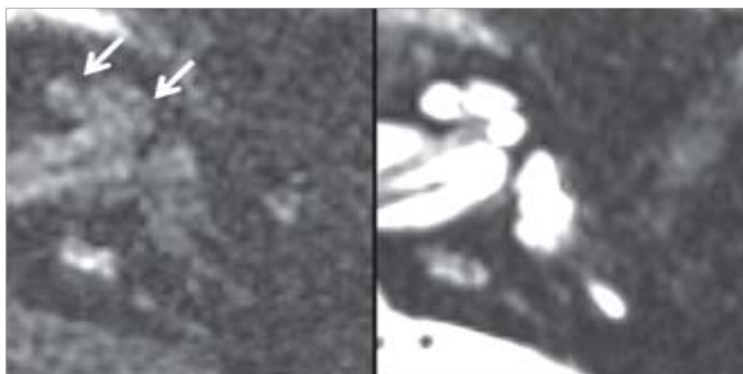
Hydrops-negative cochlea in two dimensional FLAIR sequence (left) and CISS sequence (right). 2D-FLAIR images visualizes low signal intensity region in cochlear basal turns with white arrows [11].
